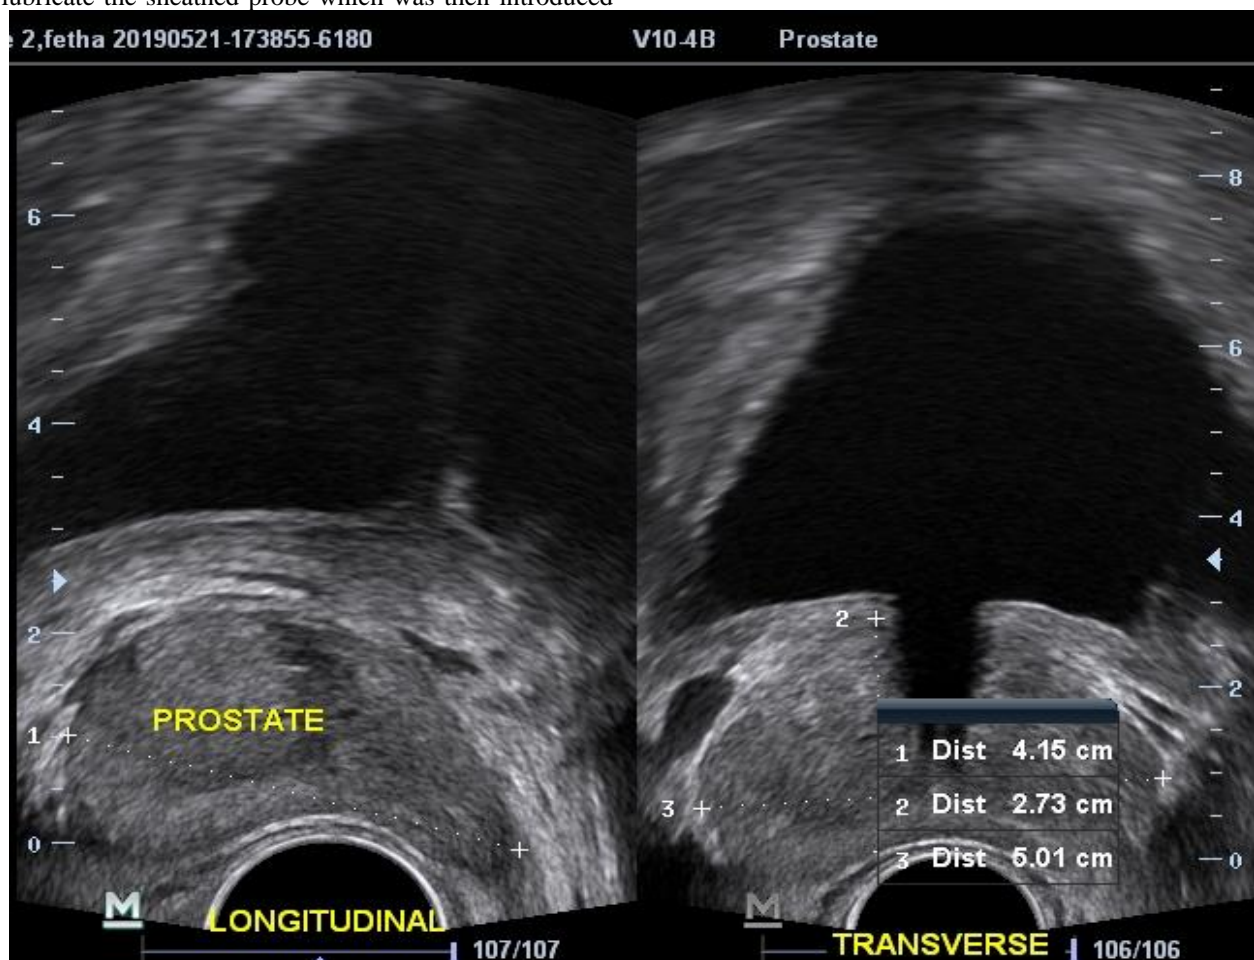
Longitudinal and transverse views of Transrectal ultrasound showing the measurement of the prostate volume.
